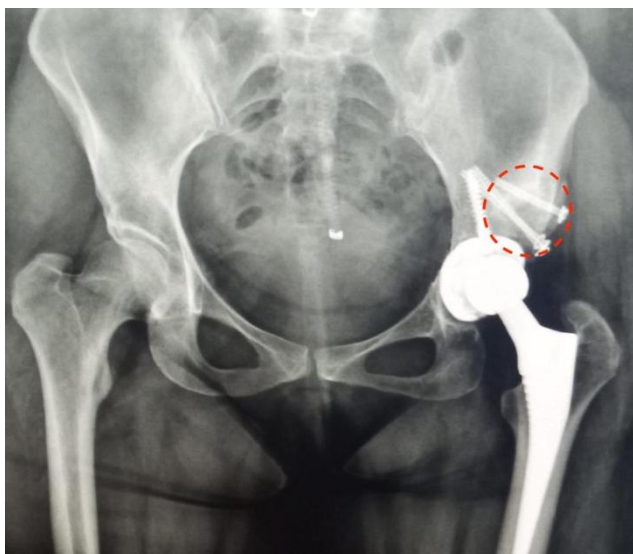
Postoperative x-ray of the left hip with implanted hip prosthesis two months after surgery in an anterior-posterior view. The former femoral head (red circle) was attached with screws to the latero-caudal area of the original acetabulum.
